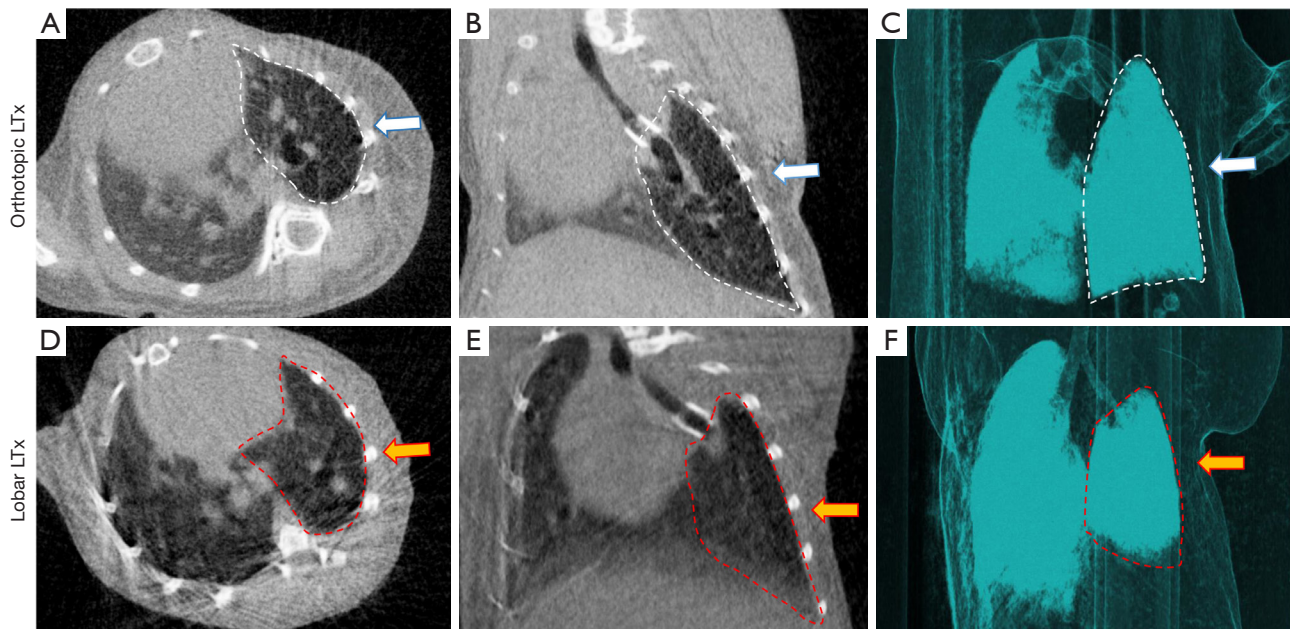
Micro-computed tomography was performed 28 days after transplantation to evaluate the size match for lobar LTx. (A-C) For orthotopic left LTx. (D-F) For lobar LTx. White and orange arrows represent transplanted lungs. LTx, lung transplantation.
